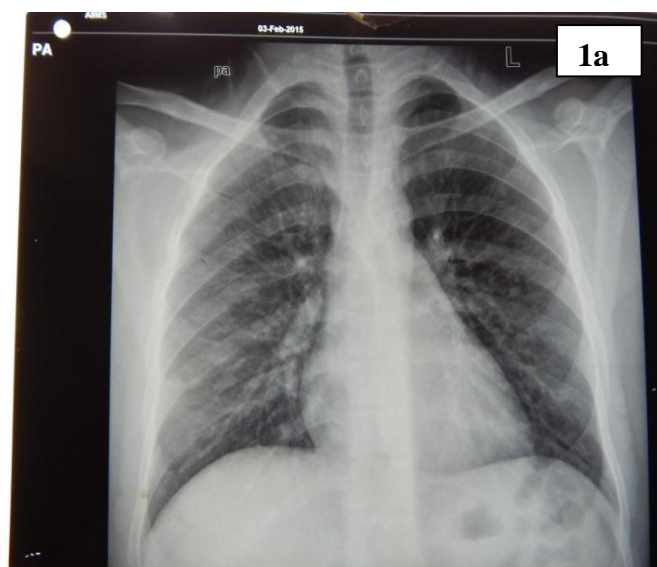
X-ray Chest PA view showing normal lung fields. 1b X-ray Pelvis with both hip AP view showing soft tissue density in right iliac region. No evidence of calcification or bony destruction is noted
